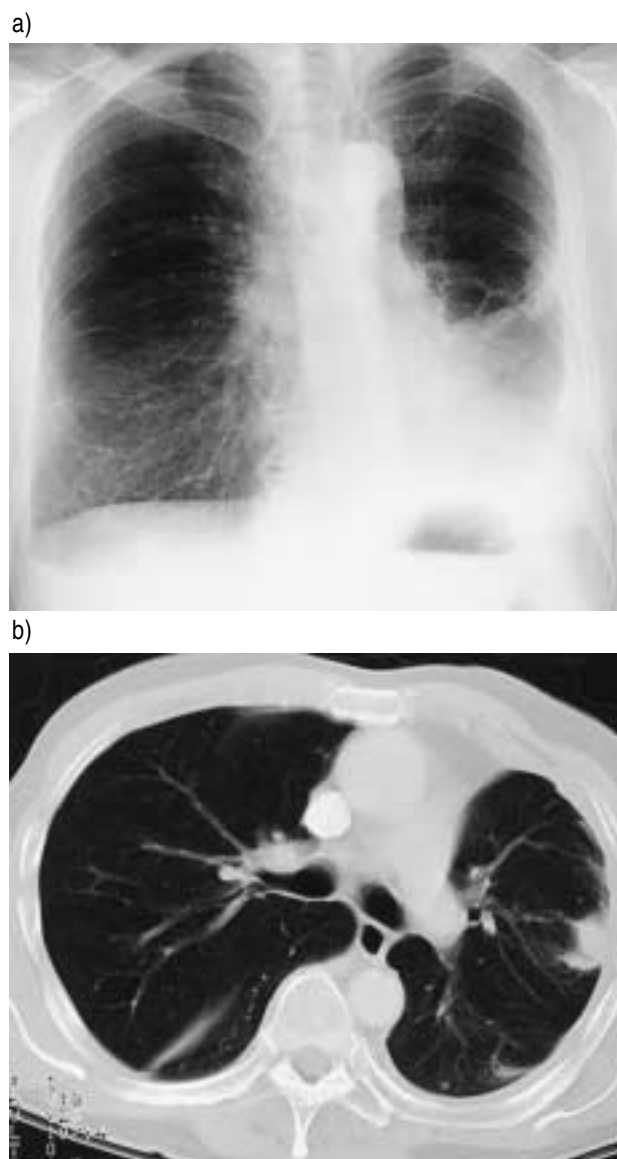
a) Chest radiograph of patient No. 9, frontal view. Bilateral pleural thickening is visible, more advanced on the left side where there is a small amount of pleural fluid and a rounded atelectasis. b) Computed tomography scan of patient No. 9, showing small round left-sided atelectasis.
